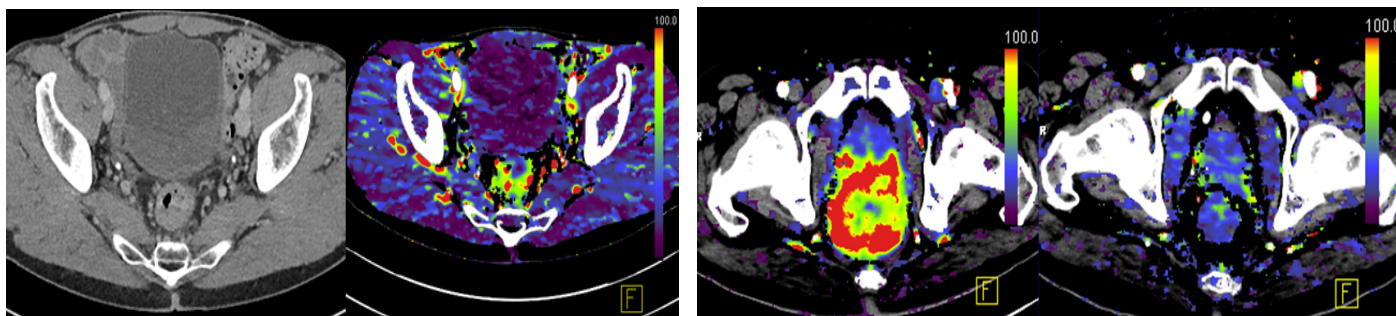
Left- perfusion CT scan showing: left -rectal tumour; right - functional map of blood flow; Right- perfusion CT pre and post CRT demonstrating a decrease in rectal cancer blood flow post chemoradiation. (Courtesy V Goh)
